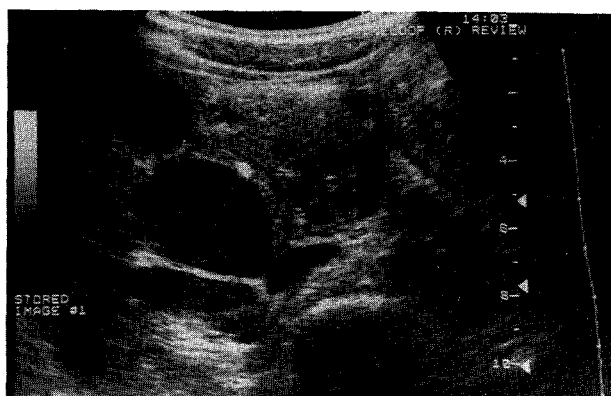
Follow-up sonography showed partial liquefaction with septa formation in the lesion, highly suggestive of resorption of the haematoma.
